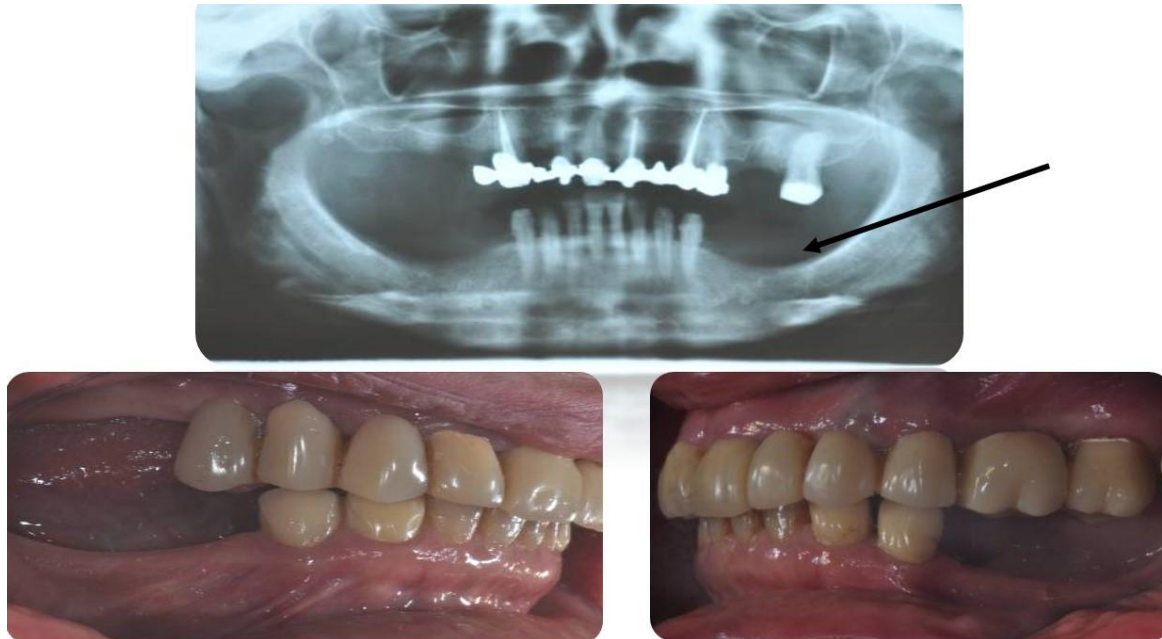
Radiograph and photos showing mandible before verticle ridge augmentations.
